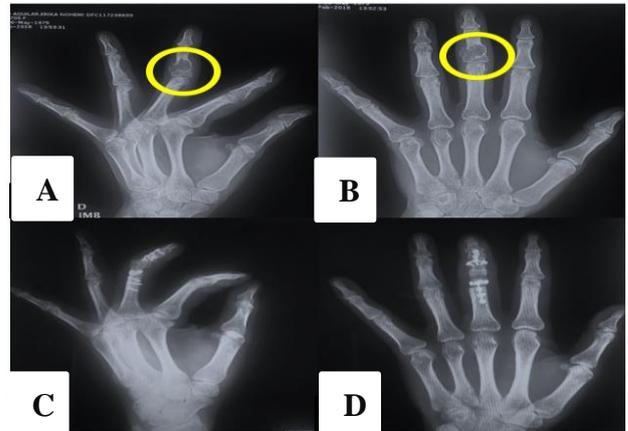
A) Oblique radiograph, B) A-P radiograph of the left hand, C) postoperative oblique radiograph, D) postoperative A-P radiograph of the right hand.
